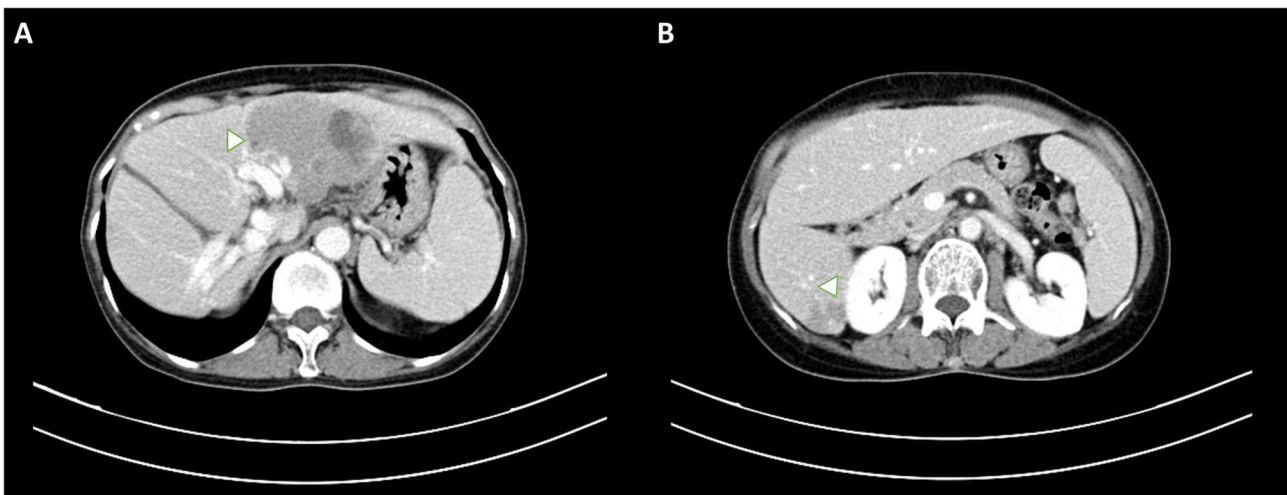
Dynamic abdominal computed tomography revealing two hypo-enhanced lesions in the liver. (A) Lesion located in segment 2/4a, demonstrating hypo-enhancement on arterial phase imaging. (B) Lesion in segment 6, showing similar hypo-enhancement characteristics.
